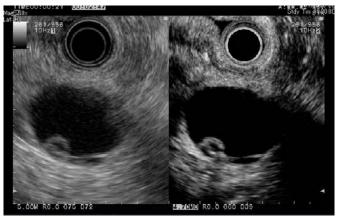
Endoscopic ultrasonography showed "cyst in cyst" appearance and a mural nodule in the cystic lesion.
